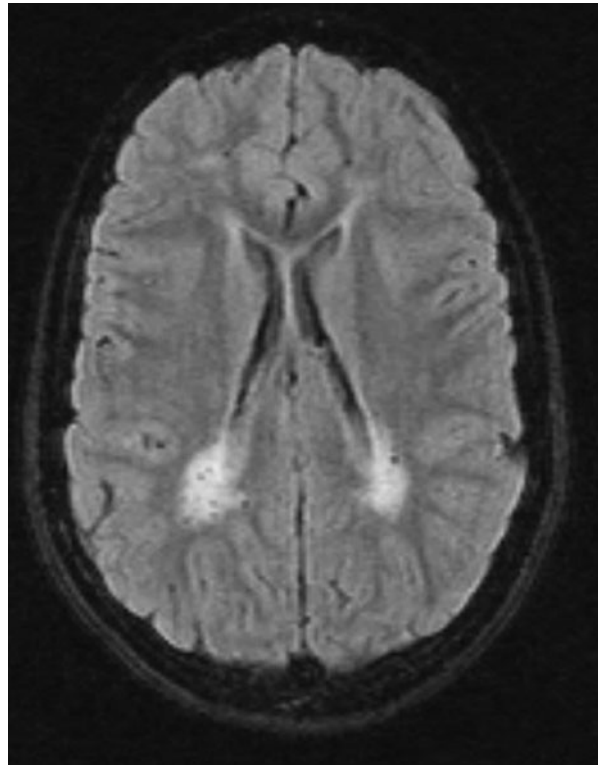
A 9 year-old boy with XALD. In this FLAIR sequence from a brain MRI there are marked T2/FLAIR hyperintense lesions in the white matter surrounding the occipital horns of the lateral ventricles.
